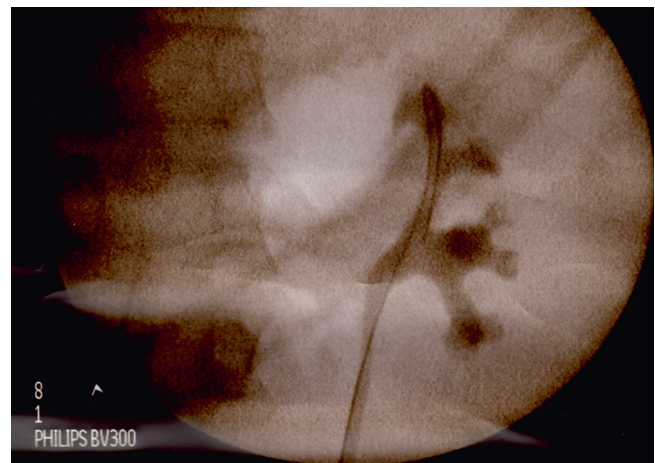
Guidewire within the upper pole and renal pelvis on single shot X-ray. Retrograde study used to demonstrate anatomy
